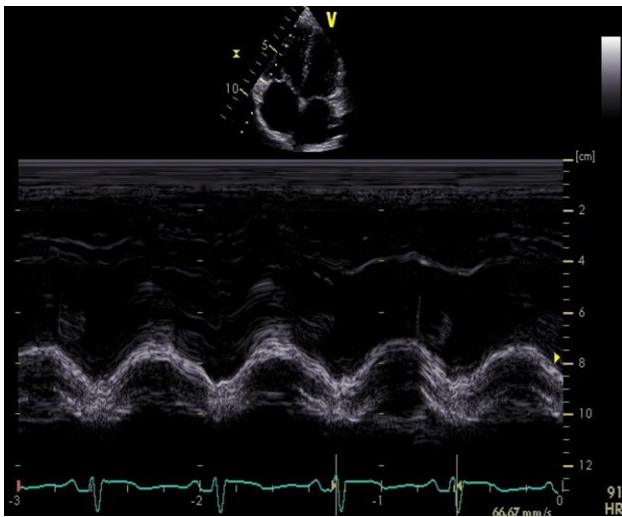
Trans-thoracic echocardiography image showing dilated right ventricle with normal systolic function assessed by TAPSE (TAPSE: tricuspid annular plane systolic excursion) (reprinted with permission of the patient)
